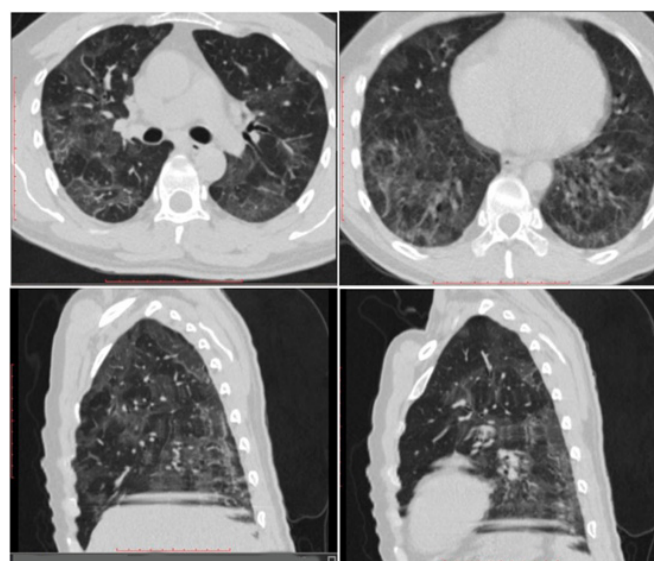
CT scan thorax case 1 on 57th day of illness.
